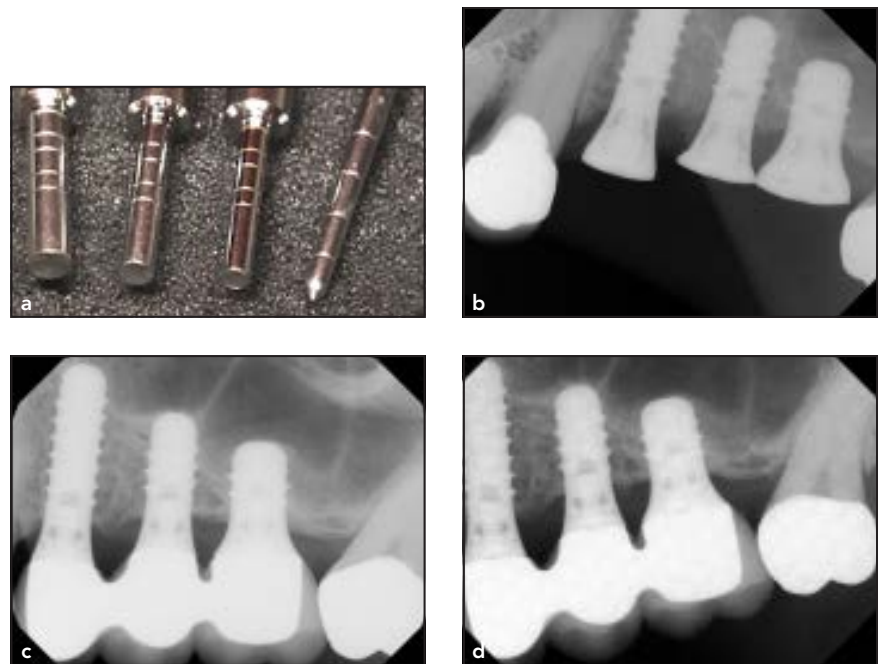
Bone remodeling around implants placed using OFSE, without a bone graft. (a) Instrumentation used. (b) Periapical radiograph taken immediately after implant placement in the left posterior maxilla. (c) Periapical radiograph 1 year after implant placement. (d) Periapical radiograph taken 5 years after implant placement. Note in (c) and (d) the stable dome of bone at the apex of the implants.
